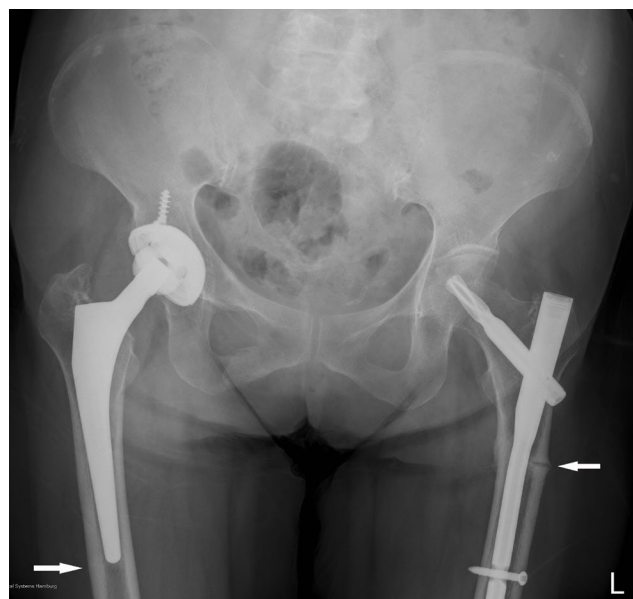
Postoperative 9 months later, radiographs of the left femur showed a poor healing in the fracture despite discontinuing alendronate therapy.
